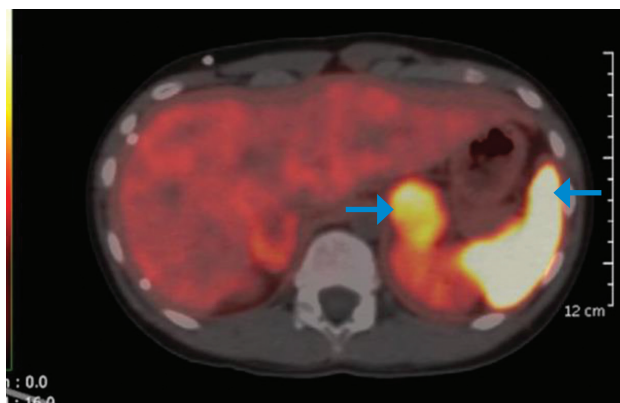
Ga-68 DOTATATE showing scan evidence of somatostatin receptor avid disease in bilateral suprenal lesions with SUV_{max} 9.7 on the right suprenal soft tissue and SUV_{max} 17.7 on the lobulated left suprenal soft tissue (blue arrows).
